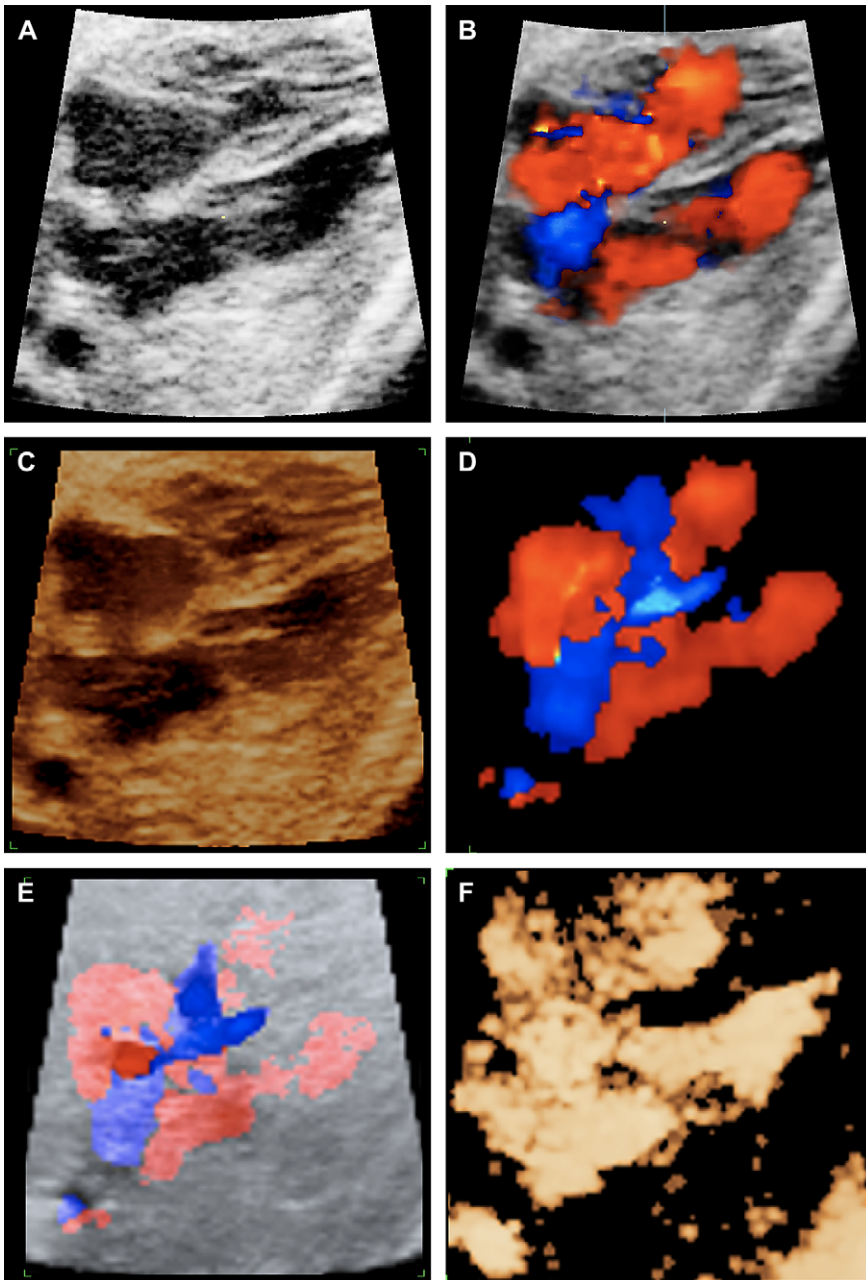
Examples of cross-sectional and rendered views of a volume acquired from an initial four-chamber view (normal fetal heart at 29 weeks' gestation). All images were generated from the same diastolic frame seen from caudally. *Cross-sectional images:* (A) B-mode. (B) Color duplex with biventricular inflow (in red). *Rendered images:* (C) Surface-rendered view, cropped to display only the cranial half of the heart. (D) Color-only rendering of the whole volume with display of hepatic veins and inferior vena cava (blue) and ventricular inflow. (E) Glass-body region of interest as in (D), but with transparent tissue rendering over color Doppler. (F) inversion mode (thin volume slice cropped to display only the four-chamber plane).
